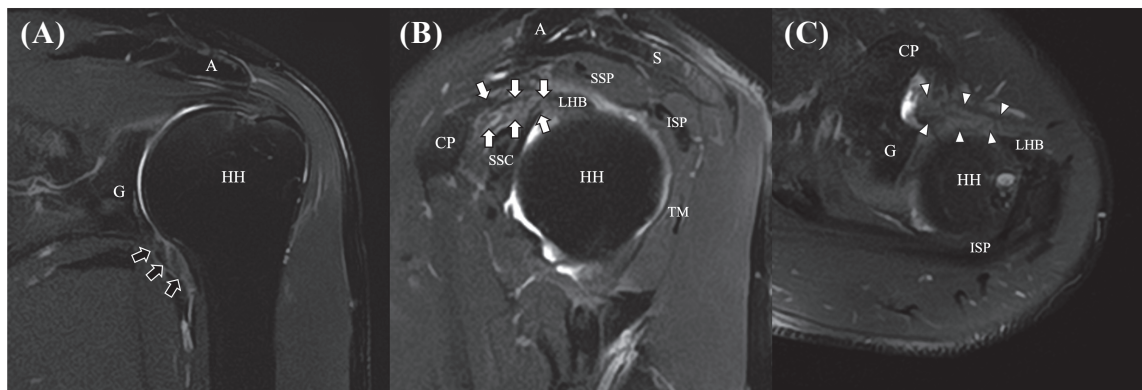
Magnetic Resonance Imaging (MRI) Findings in Frozen Shoulder
